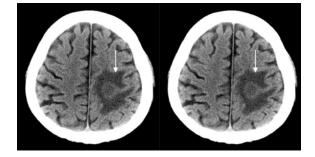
1 in 3 cases of uncorrected diagnosis toxoplasmosis. A 35-year-old HIV patient shows single rim-enhancing isodense lesion with perilesional edema at the left frontoparietal lobe (arrow), representing toxoplasmosis by CT. In final diagnosis was tuberculoma proved by therapeutic treatment
